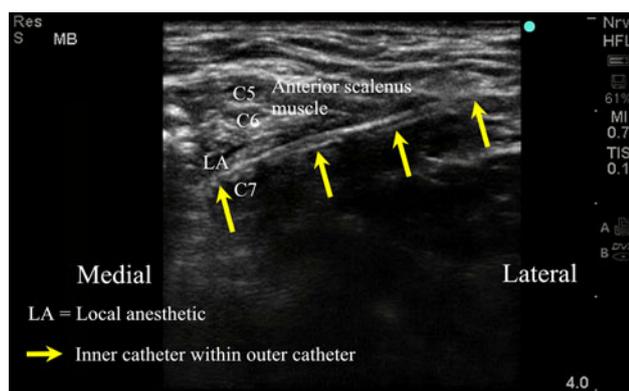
An ultrasound image showing hydrodissection using D5W via the catheter-through-needle unit, adopting an in-plane approach with the high-frequency linear transducer. This technique allows the unit to traverse between the C6 and C7 roots
